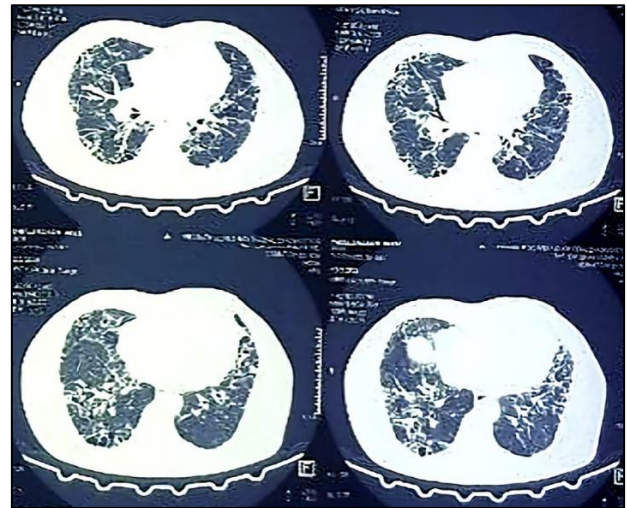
Axial view of HRCT-interlobular septal thickening and honey-combing appearance.
